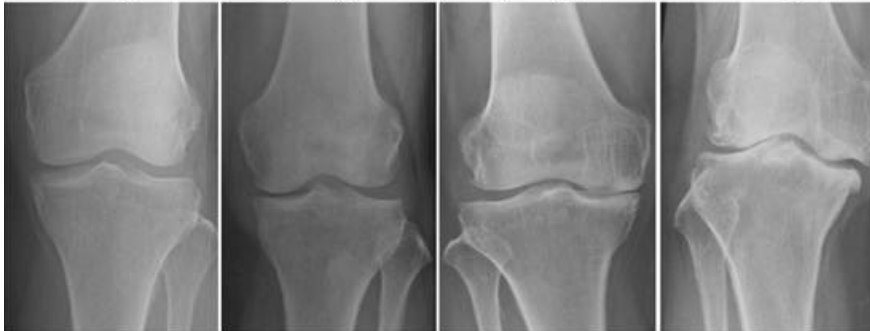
Radiographic representation of K&L scale (37)
